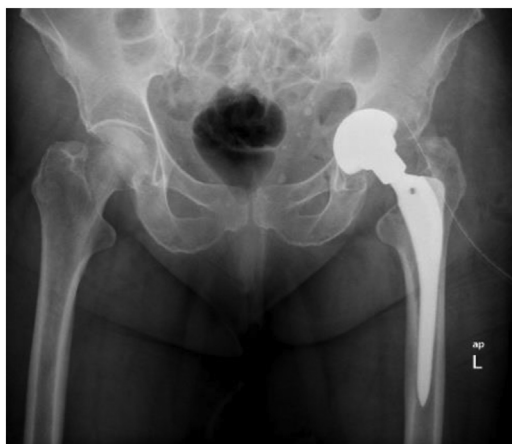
Postoperative anteroposterior radiograph after conversion of the bipolar hemiarthroplasty to total hip arthroplasty.
